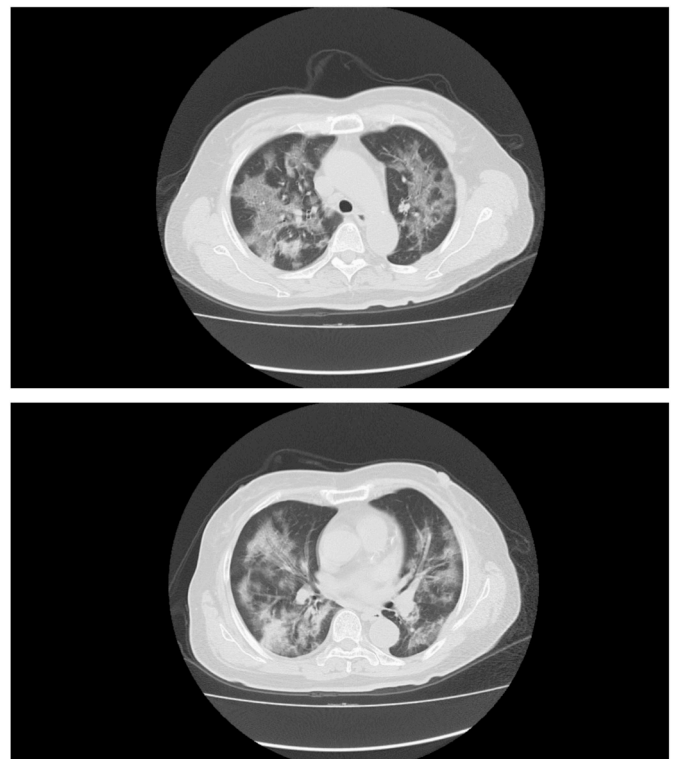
Chest CT images of the Patient. CT scans showed bilateral multiple lobular and subsegmental areas of ground-glass opacity and consolidation 9 days after symptoms onset.
